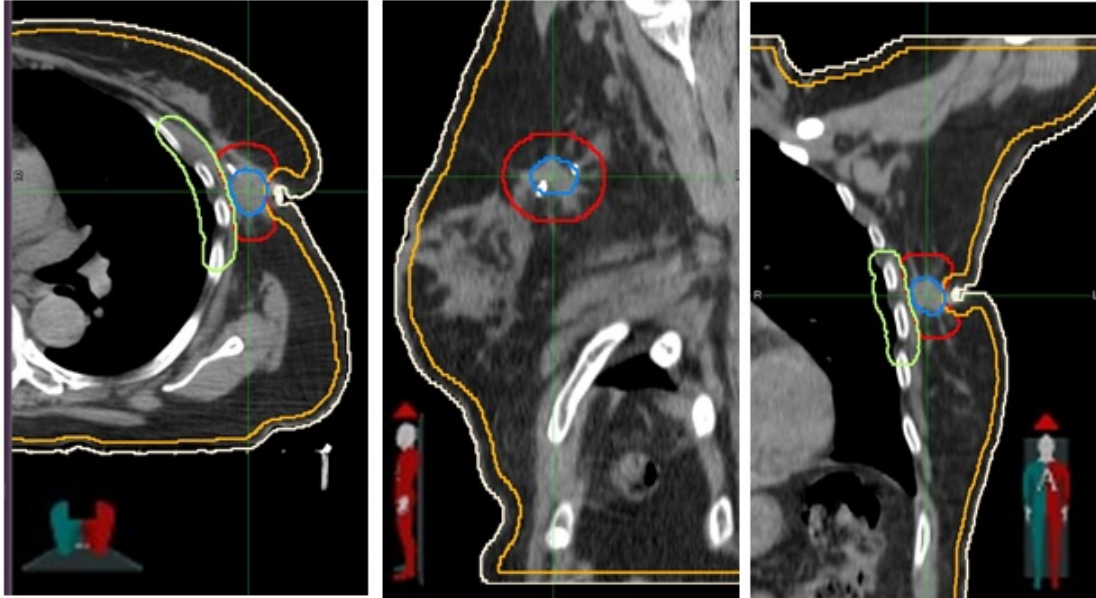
The anatomy of the breast, including contoured CTV (blue) and PTV (red), chest wall (green), and skin (orange) observed in 3 orthogonally reconstructed CT imaging plans in the TPS. From left to right, the planes are referred as axial, sagittal, and coronal
